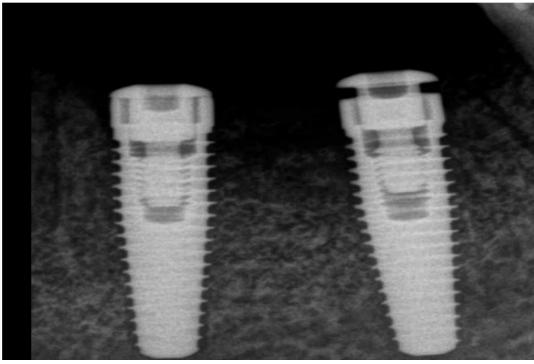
Pre operative radiograph showing no bone loss around the implants
